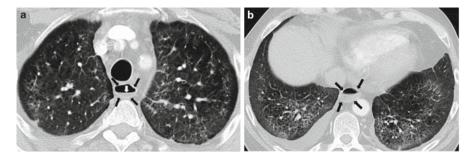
Esophageal Abnormalities on HRCT. (a) shows a dilated esophagus (*black arrows*) with air-fluid level (*white arrow*) adjacent to the trachea in a patient with pulmonary fibrosis due to scleroderma and esophageal aperistalsis; (b) shows the dilated esophagus (*black arrows*) with air-fluid level in the lower thorax (same patient)
